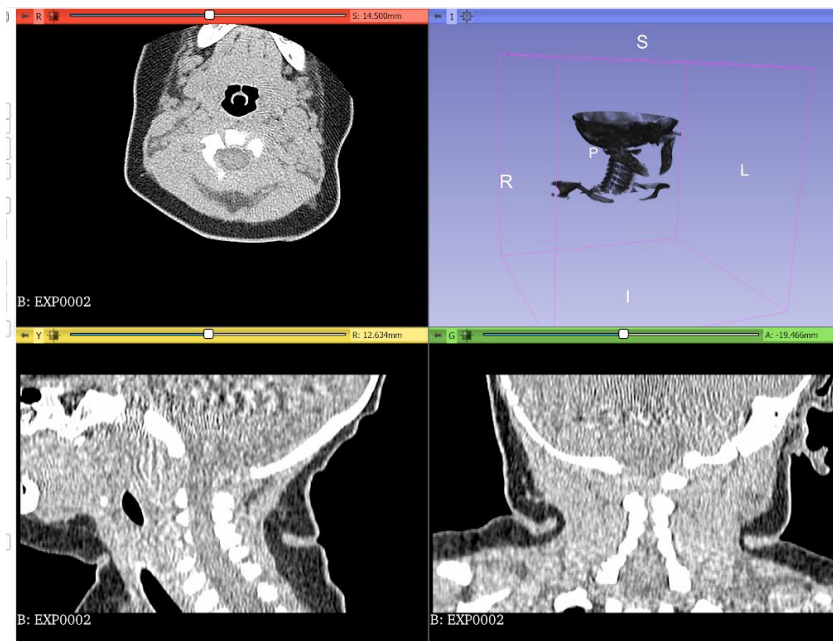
A screenshot of the 3D Slicer viewer, which shows the CT scan of the neonate.
